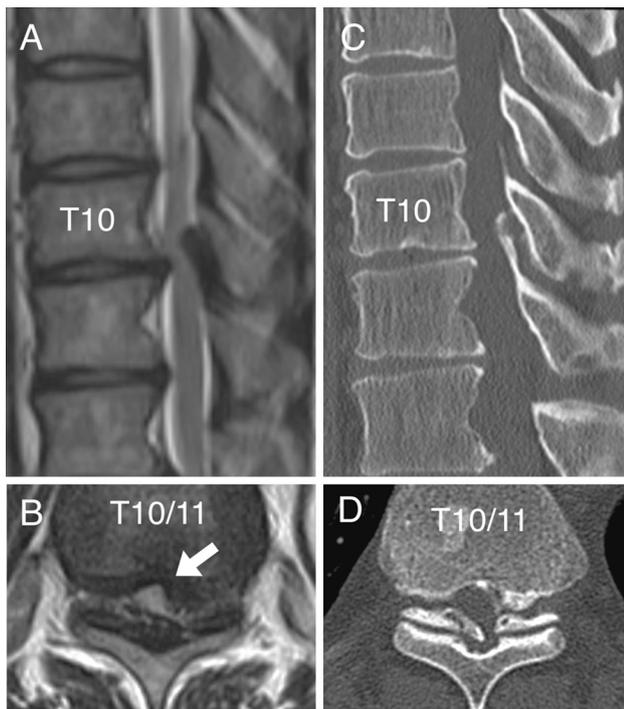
Case 2. MR images and CT scans obtained before the first operation. Sagittal (a) and axial (b) T2-weighted images show the compressed spinal cord at the T10–11 intervertebral level (arrow in b). Sagittal reconstruction (c) and axial (d) CT scan shows OLF and OPLL at T10–11 level
